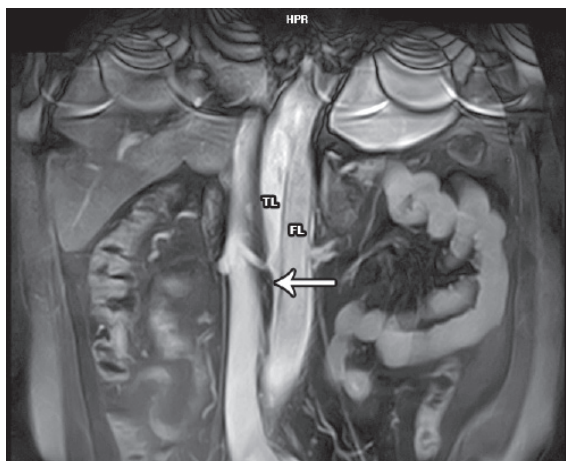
Magnetic resonance imaging study from the present case of a 56 year-old man.
